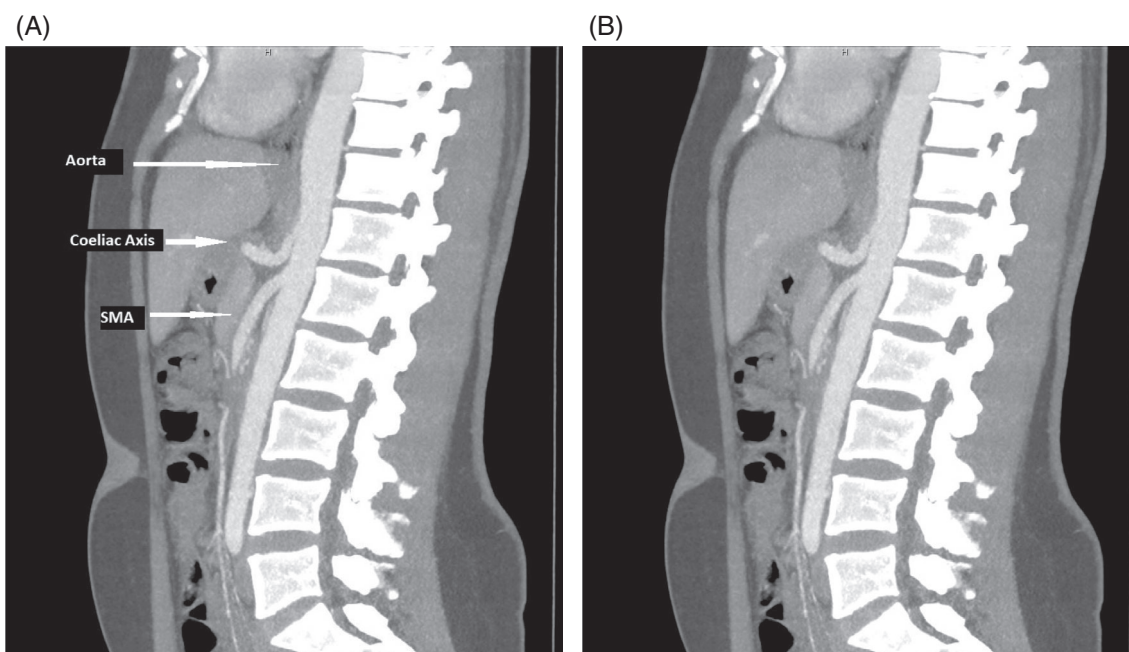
(A) Computed tomography angiography (CTA) of abdomen MIP, sagittal plane of the aorta at the level of the coeliac axis origin. (B) CTA of abdomen MIP, sagittal plane of the aorta at the level of the coeliac axis origin.
